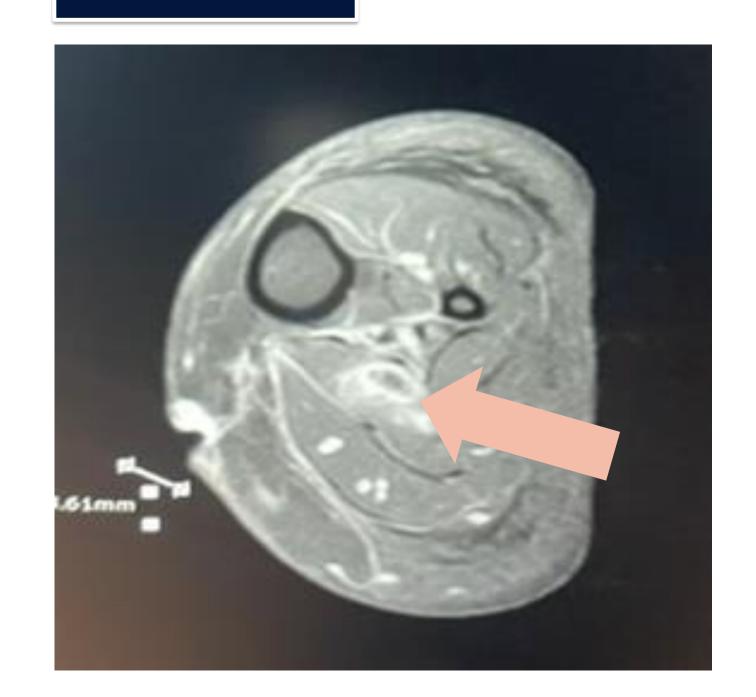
MRI LLE(Axial view): Multiple subcutaneous abscess, intramuscular abscess, and myositis of soleus muscle.
